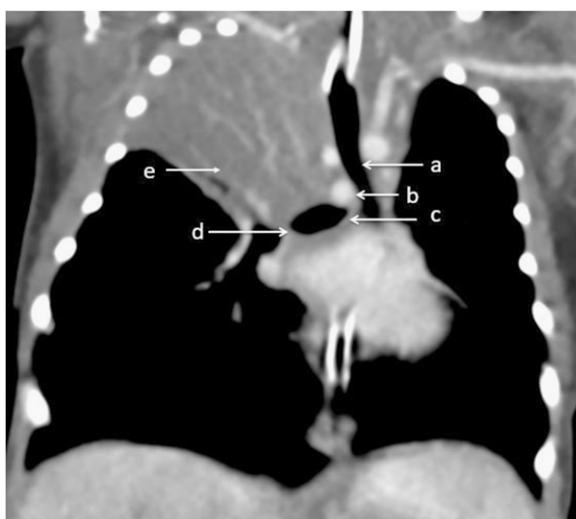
Coronal view of chest computed tomography scan showing A) trachea, B) left pulmonary artery with an abnormal course around the trachea at its bifurcation, causing stenosis of the right bronchus, C, D) areas of stenosis of the right main bronchus, and E) atelectatic upper lobe of the right lung.
